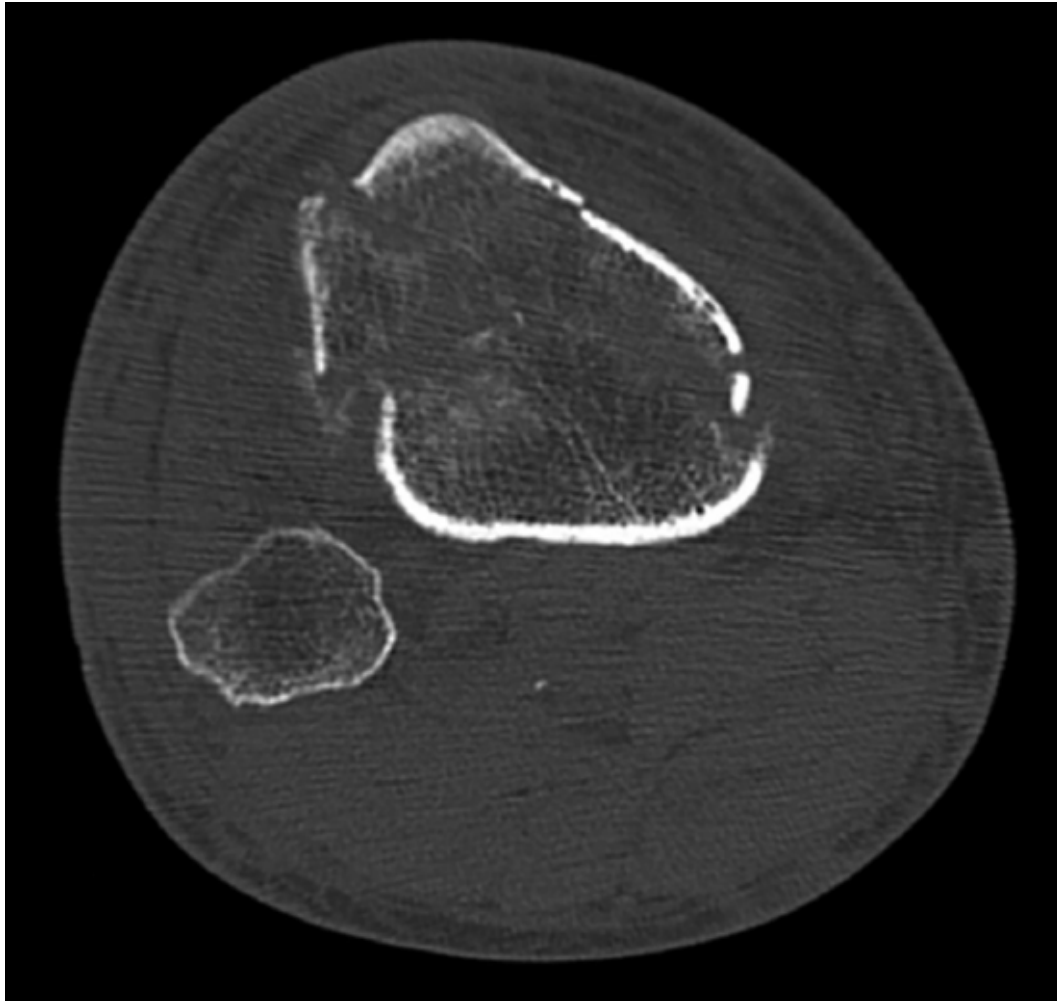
Axial (33) and sagittal (34) CT images showing the independent tibial tubercle fracture fragment component of a bicondylar tibial plateau fracture.
